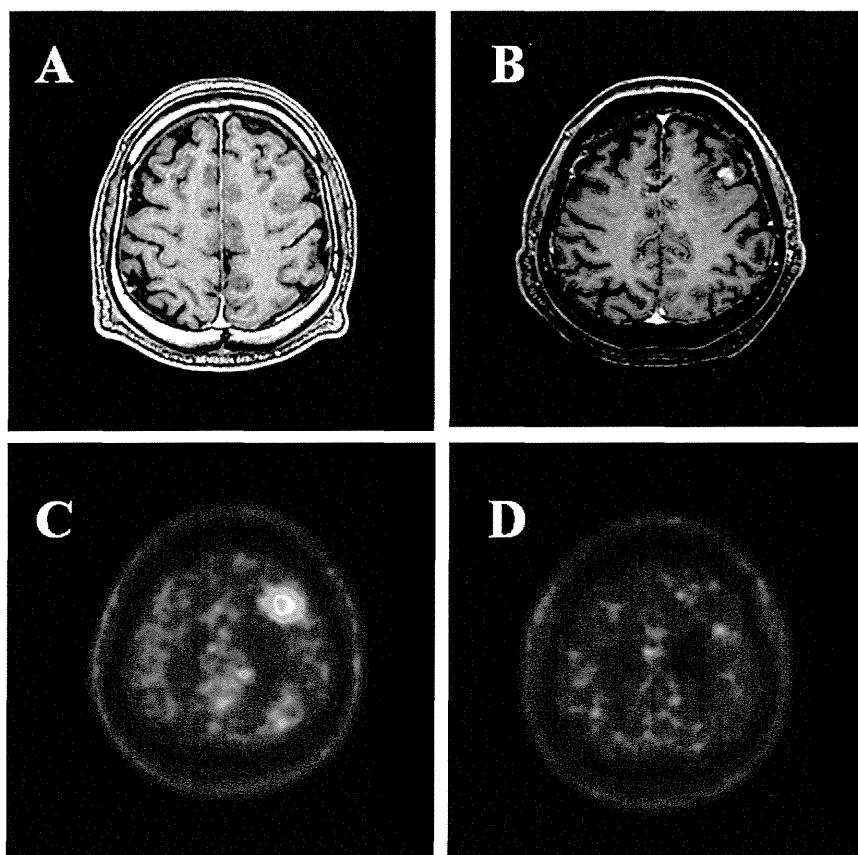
A 53-year-old male patient with non-small cell lung cancer. Gadolinium-enhanced MRI before SRT-IMRT (A) and 3 months after SRT-IMRT (B), and MET-PET before SRT-IMRT (C) and 3 months after SRT-IMRT (D). Metastatic brain tumor in the left frontal lobe is demonstrated, showing no Gd-enhancement at all on MRI but high MET uptake on PET (A and C). At 3 months after SRT-IMRT, the volume of Gd-enhanced lesion on MRI increased, although MET uptake at the lesion distinctly decreased (B and D). The lesion remained stable in size on MRI after a long-term follow-up, which was assumed to be radiation necrosis.
